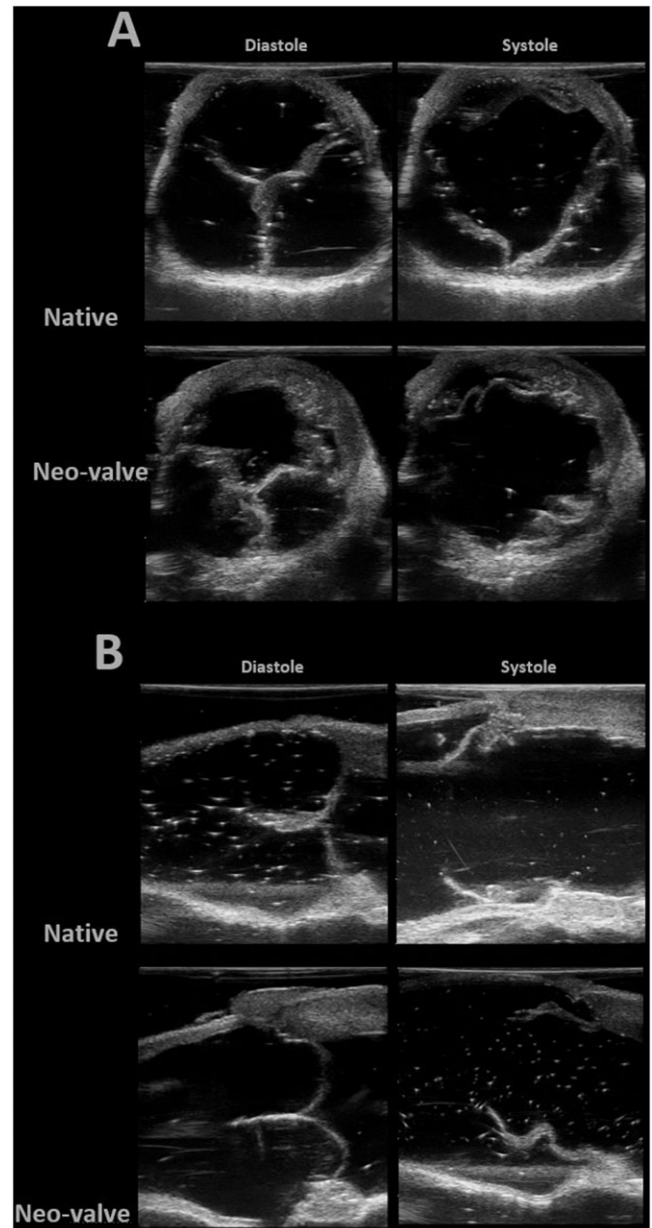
Echocardiographic images of the native and the neo-valve in (A) short-axis view and (B) long-axis view.
